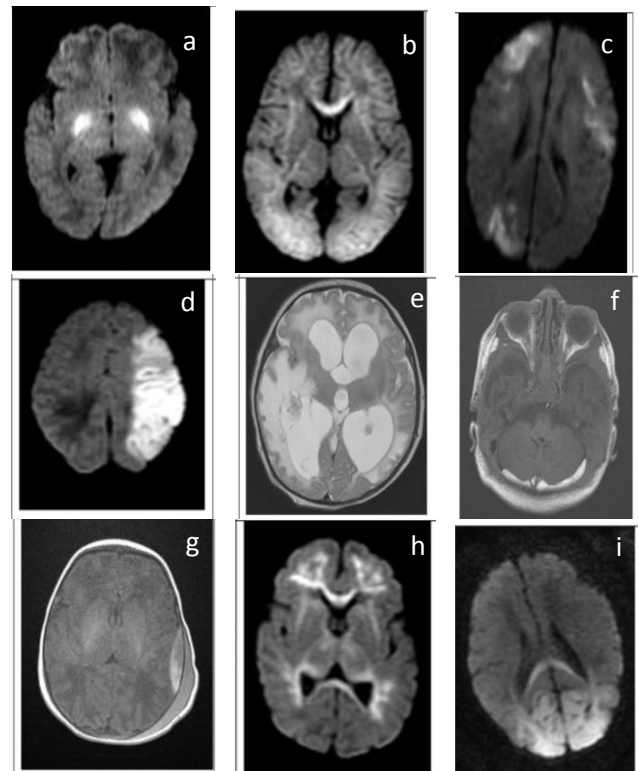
Various brain lesions; a) HIE-BGT pattern with PLIC, b) HIE- cortical and subcortical pattern, c) HIE- mild cortical subcortical pattern involving watershed areas, d) MCA territory infarct, e) Parenchymal haemorrhage, f) Subdural haemorrhage, g) Extradural haemorrhage, h) Viral encephalitis, i) Hypoglycemic MRI changes.
